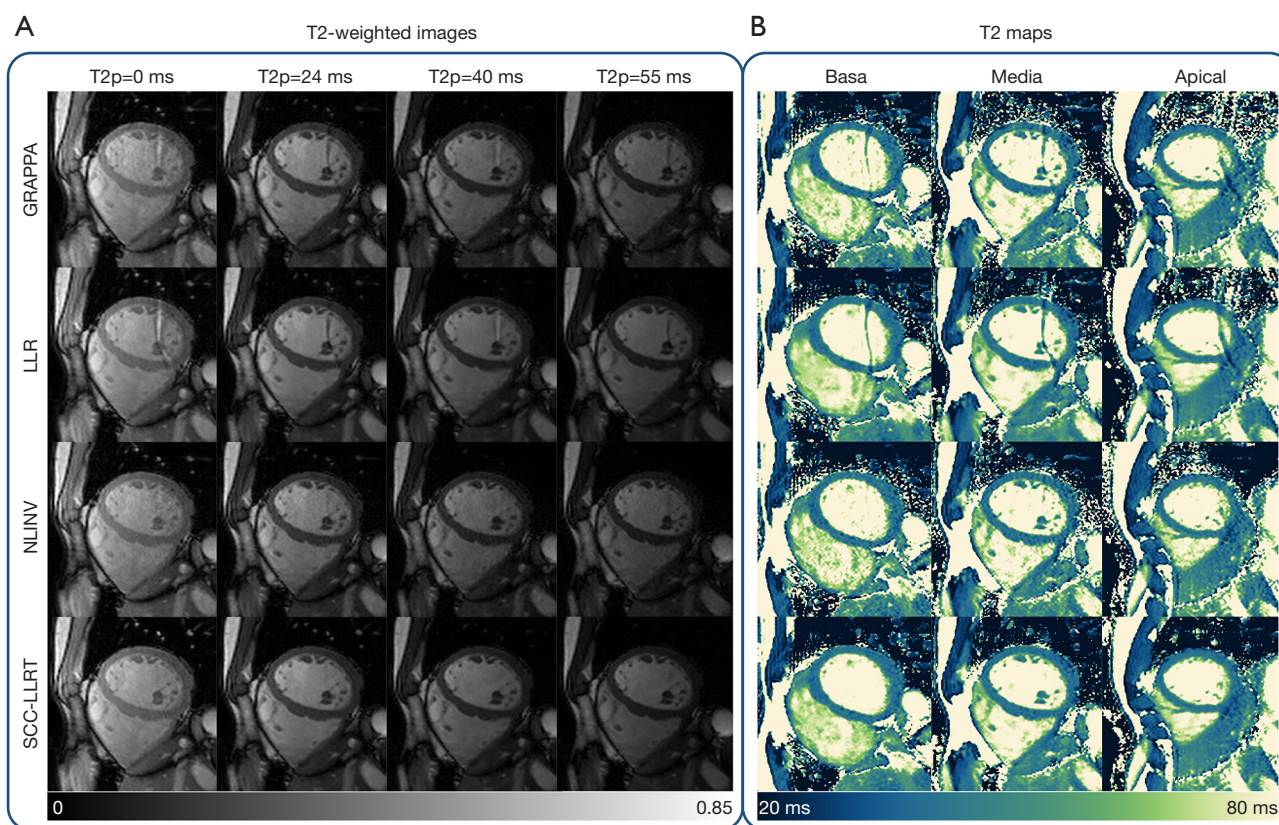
In vivo* results reconstructed by GRAPPA (Row 1), LLR (Row 2), NLINV (Row 3), and SCC-LLRT (Row 4) from the accelerated T2 mapping data for one representative healthy participant. (A) Raw T2-weighted images at the midventricular slice. (B) T2 maps at three short-axis slices. SCC-LLRT better suppressed the aliasing artifacts compared to GRAPPA and LLR. Moreover, SCC-LLRT appeared to suppress noise more effectively than NLINV. T2p, T2-prepared time; GRAPPA, generalized autocalibrating partially parallel acquisitions; LLR, locally low rank; NLINV, nonlinear inversion; SCC-LLRT, space-contrast-coil locally low-rank tensor.
